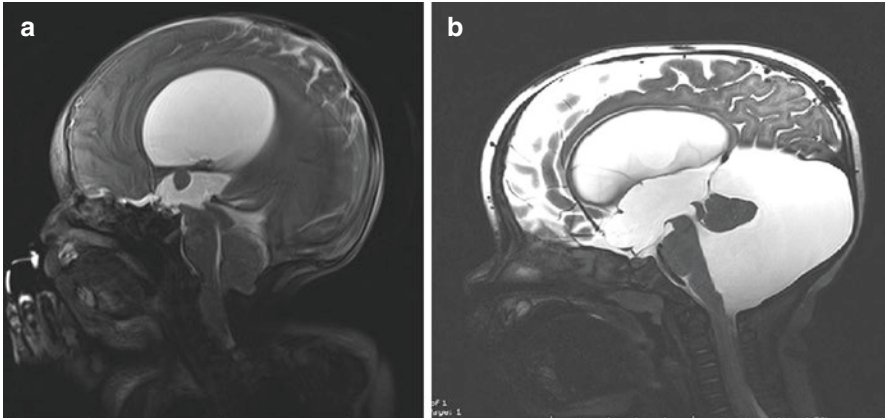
Sagittal MRI, T2-WI, congenital hydrocephalus showing thinning of the corpus callosum, dilation of the lateral and third ventricles, bulging of the third ventricular floor. (a) A newborn presenting with myelomeningocele and Chiari 2 malformation. (b) Dandy-Walker malformation in a one-year old child, consisting of hypoplasia of cerebellar vermis, and cephalad rotation of the vermian remnant, cystic dilation of the IV ventricle, lifting of the tentorium cerebelli and enlarged posterior fossa
